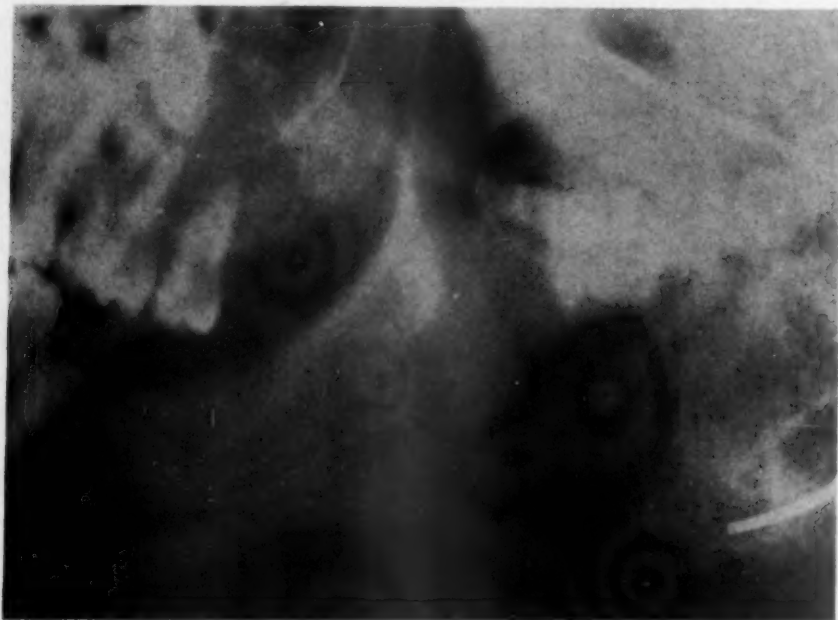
X-ray of the jaw of the same patient nine years later showing ankylosis of the condyle.
